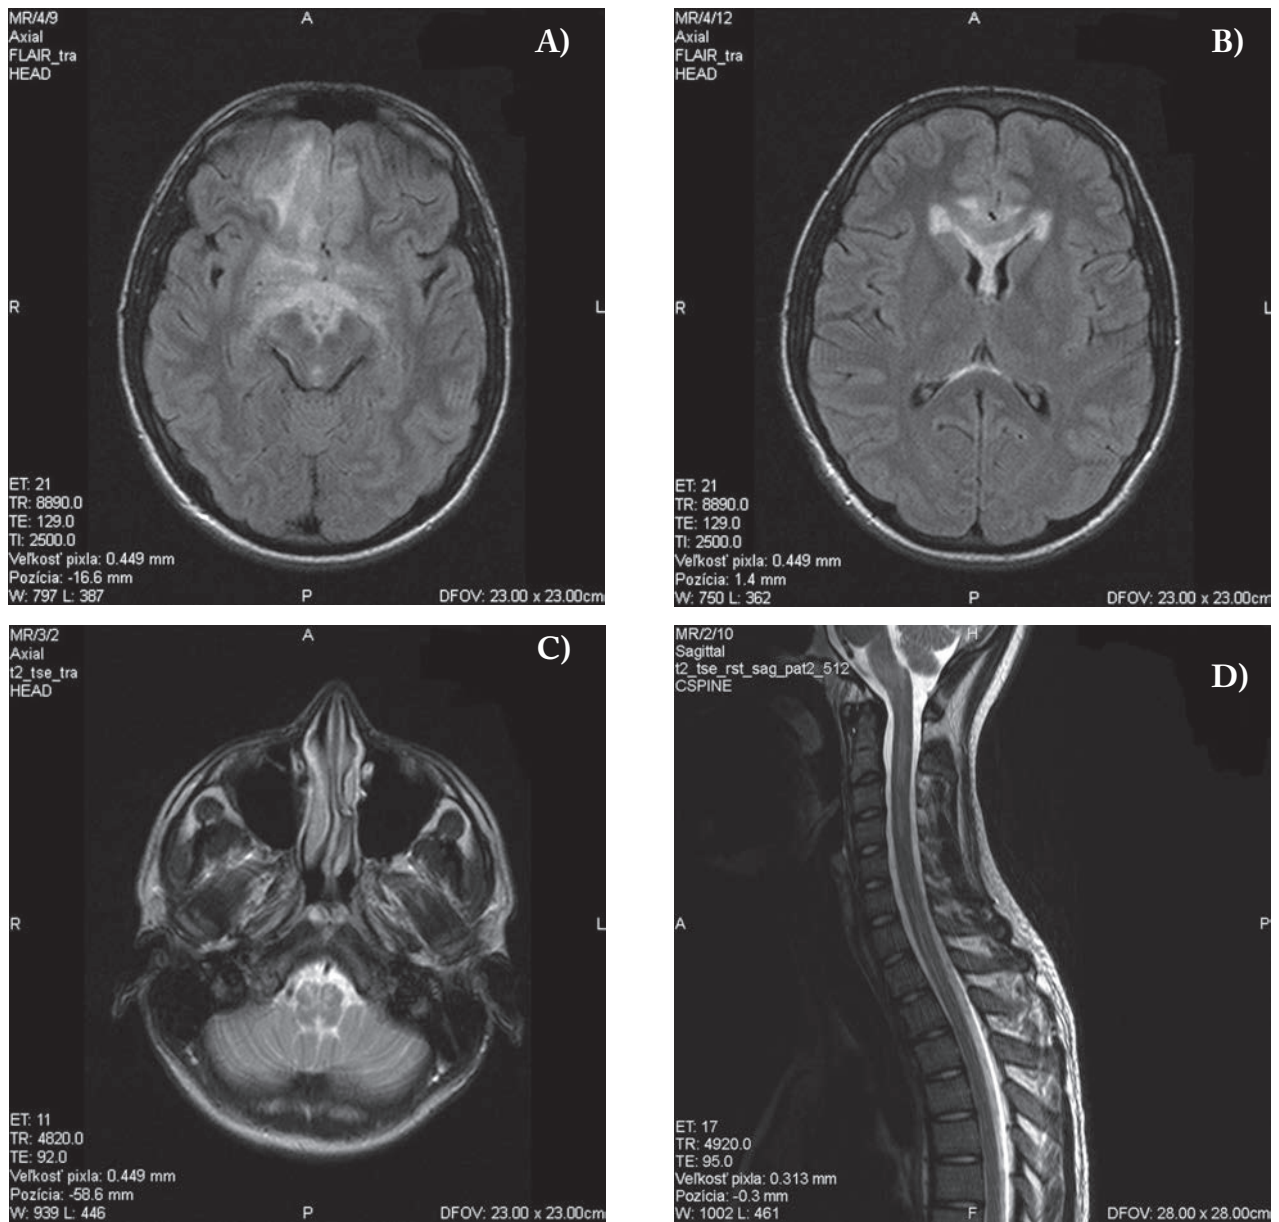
Magnetic resonance imaging of subcortical white matter and optic chiasm
